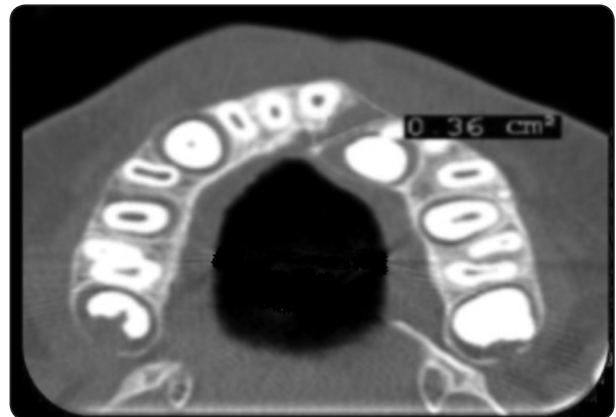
Surface area of alveolar cleft outlined and calculated on Axial CBCT sections.
